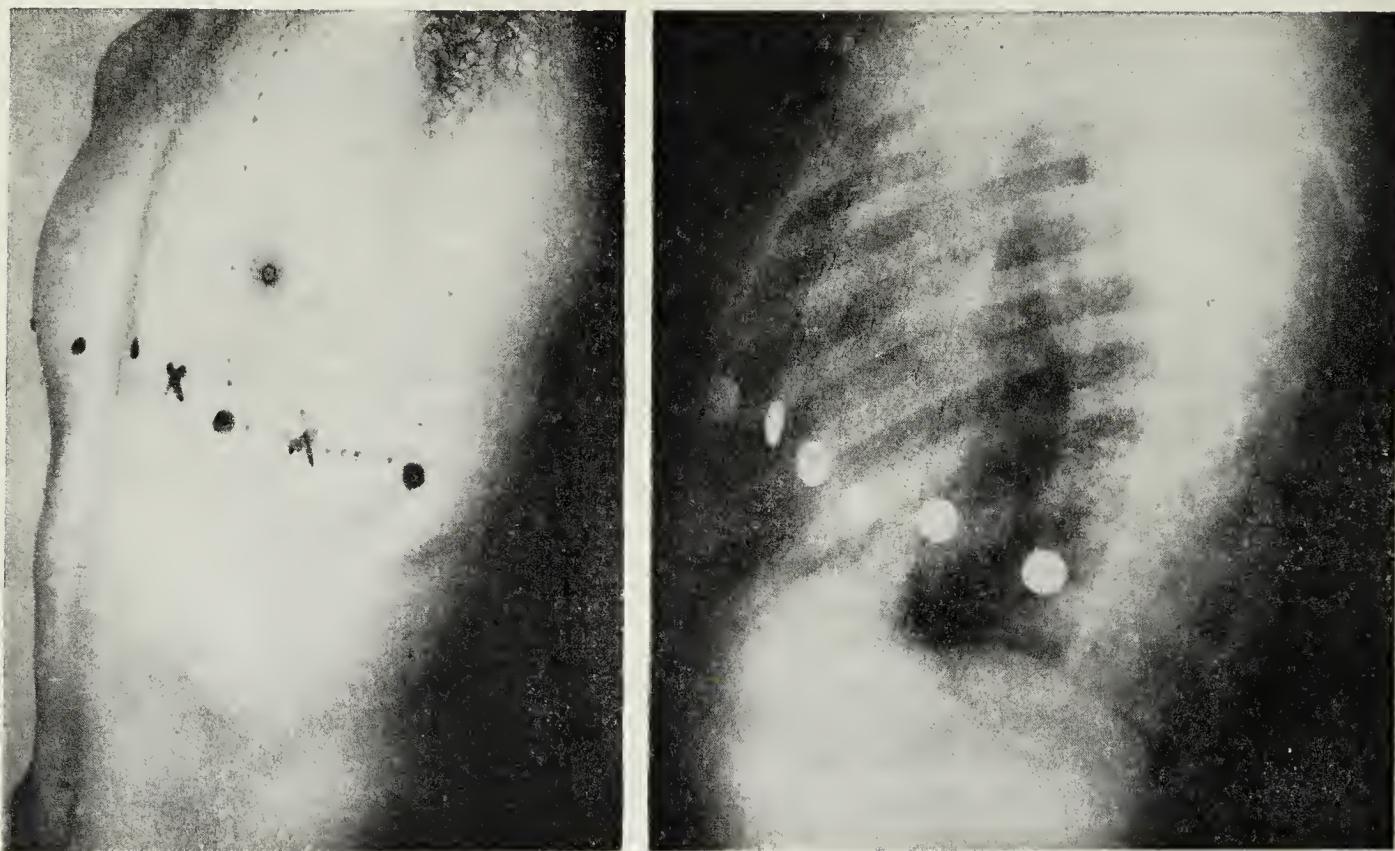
The standard precordial positions ( $V_1-V_6$ ).  $V_1$ , fourth intercostal space to right of sternum;  $V_2$ , same, to left of sternum;  $V_3$ , between  $V_2$  and  $V_4$ ;  $V_4$ , fifth intercostal space in left midclavicular line;  $V_5$ , between  $V_4$  and  $V_6$ ;  $V_6$ , plane of  $V_4$  in left anterior axillary line. The points may be determined by locating the fourth intercostal space, the midclavicular line, and the midaxillary line. Positions 1, 2, 4, and 6 are easily found; 3 and 5 may be interpolated. Leads over the back are usually taken at the level of positions 4, 5, and 6. An x-ray of the chest reveals the approximate relationships of the precordial position to the cardiae shadow in a normal individual.  $V_6$  is seen to lie posterior to the heart in most radiologic positions.
